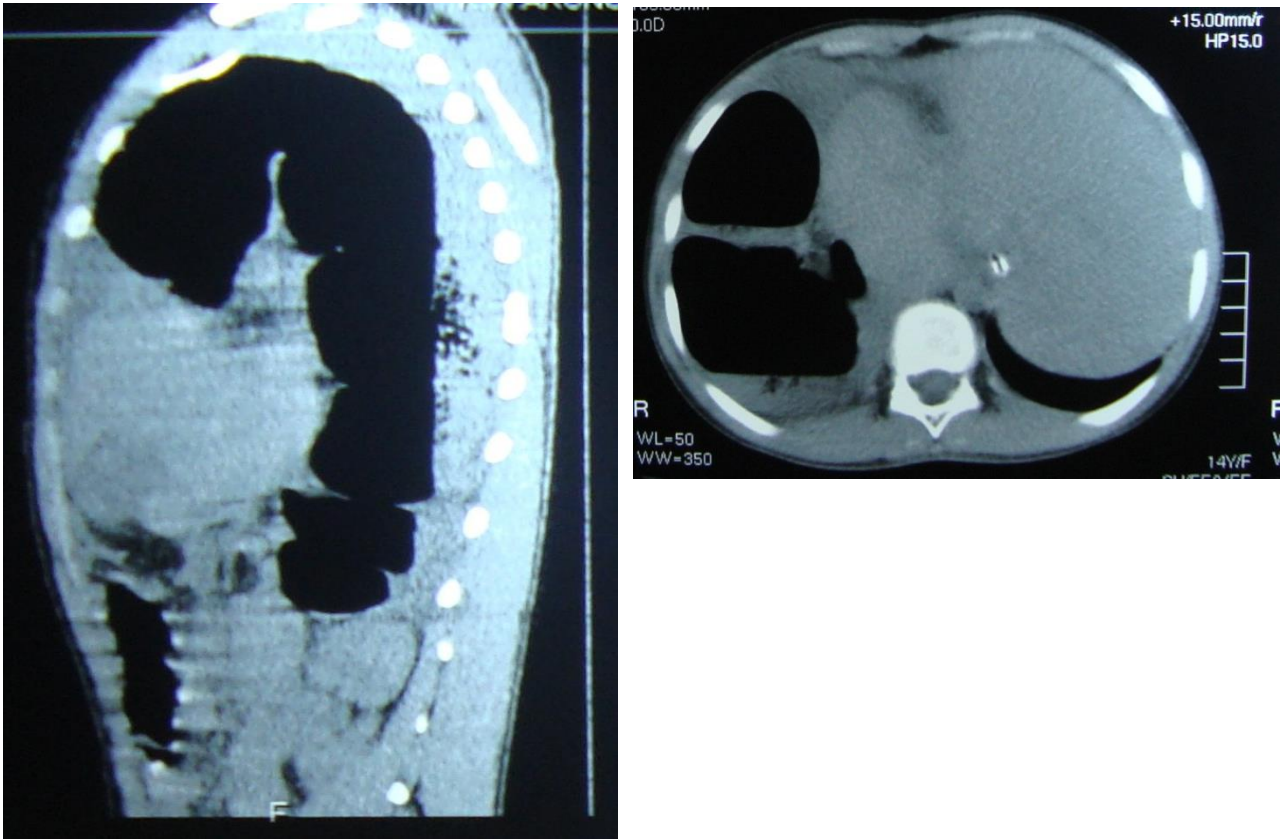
Axial and sagittal CT abdomen showing the bowel loop in the thorax
